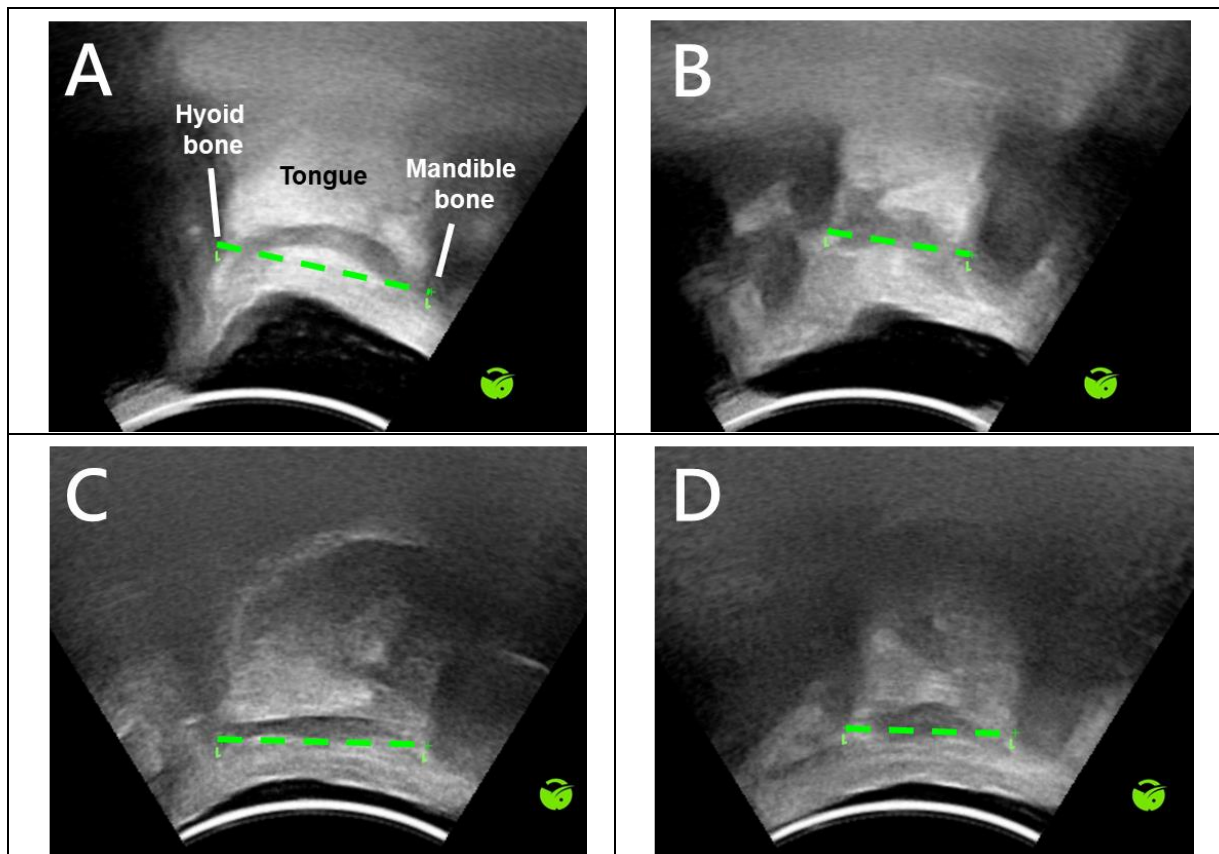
Ultrasonographic examples of pass and fail results
